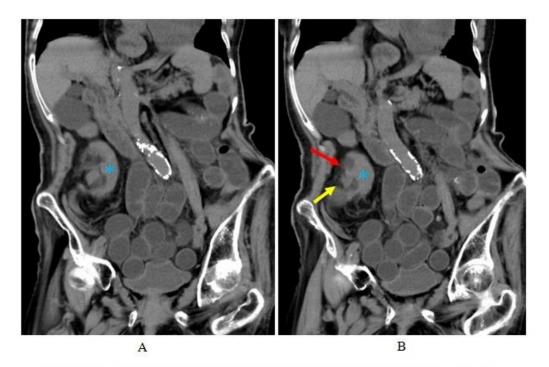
Coronal CT images depict double knots sign (A, B) red arrow, yellow arrow) adjacent to constructive cecum and ascending colon (A *).
